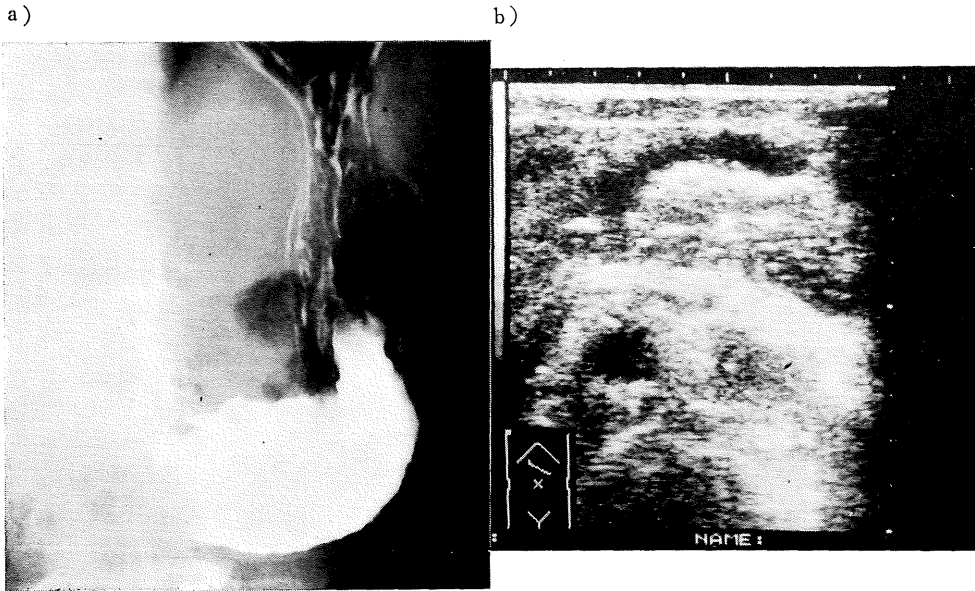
X-ray (a) and ultrasonography (b) of case 9.
